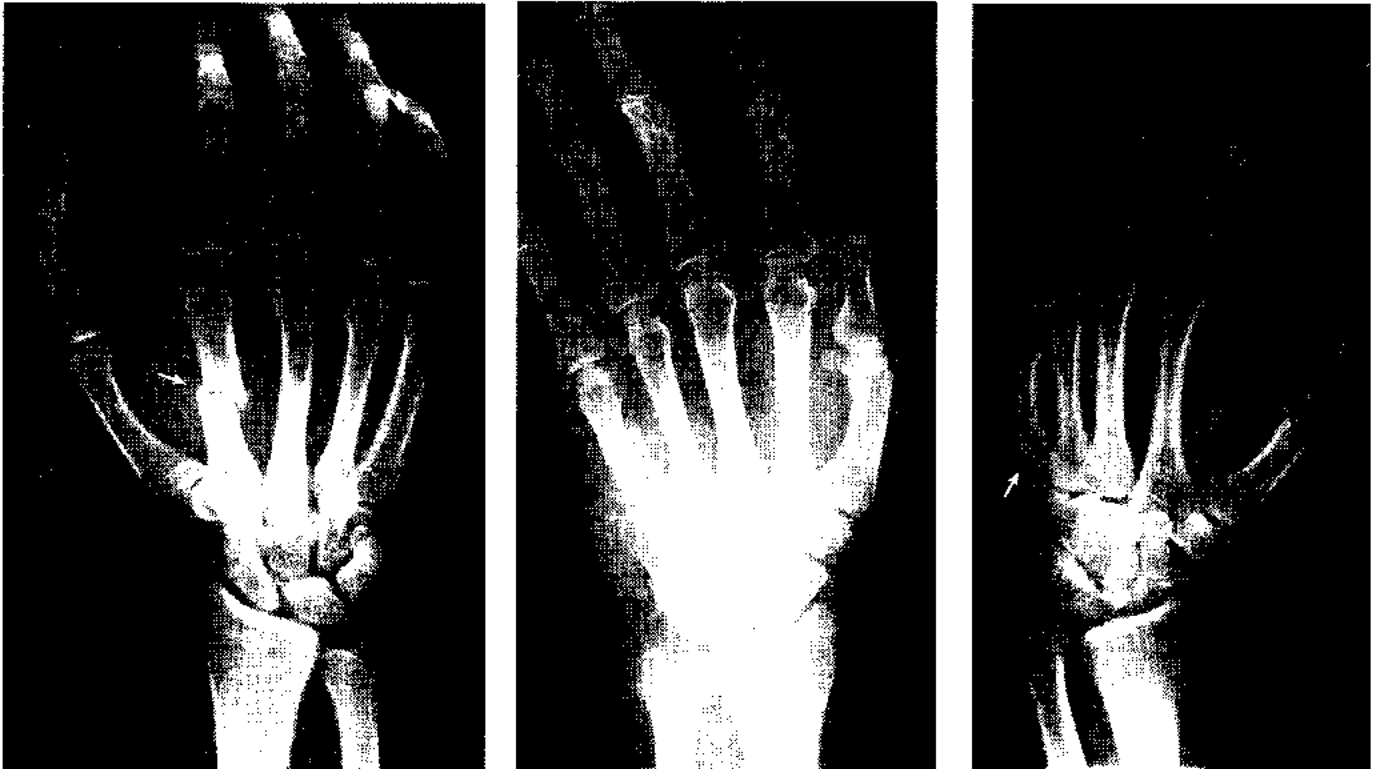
(above, left) Anteroposterior radiograph of the hand showing extraarticular fracture of the shaft of the second metacarpal.
